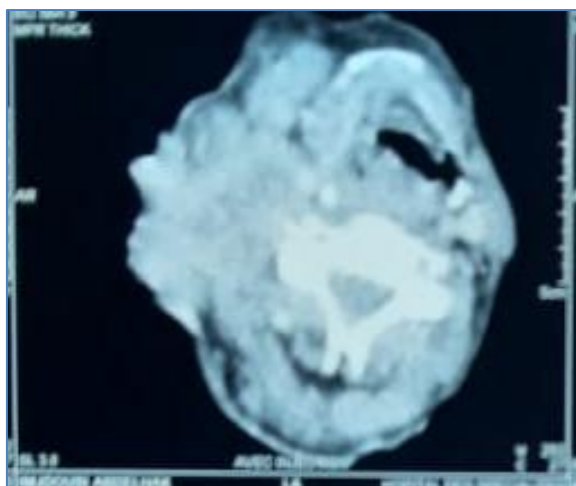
Axial CT of the neck after injection of the contrast product injecting an enormous cervical mass
